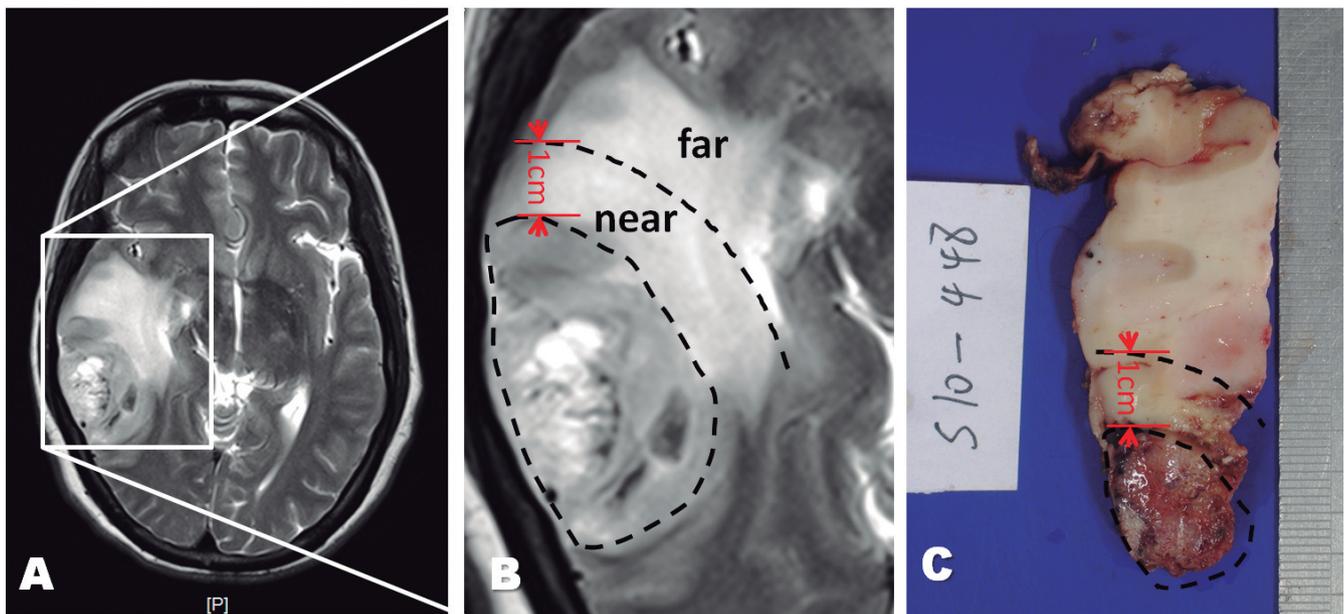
The magnetic resonance imaging (MRI) scan showed peritumoral edema, which was an unenhanced T1-weighted hypointense, T2-weighted hyperintense image (A). Using MRI-scans, PTBE was classified as being near the glioma (≤ 1 cm) and far from the glioma (> 1 cm) (B). Grossly, the primary basic structures were preserved in the field of the edema tissue with a clear boundary of the gray and white matter and a wet tender cut surface (C).
